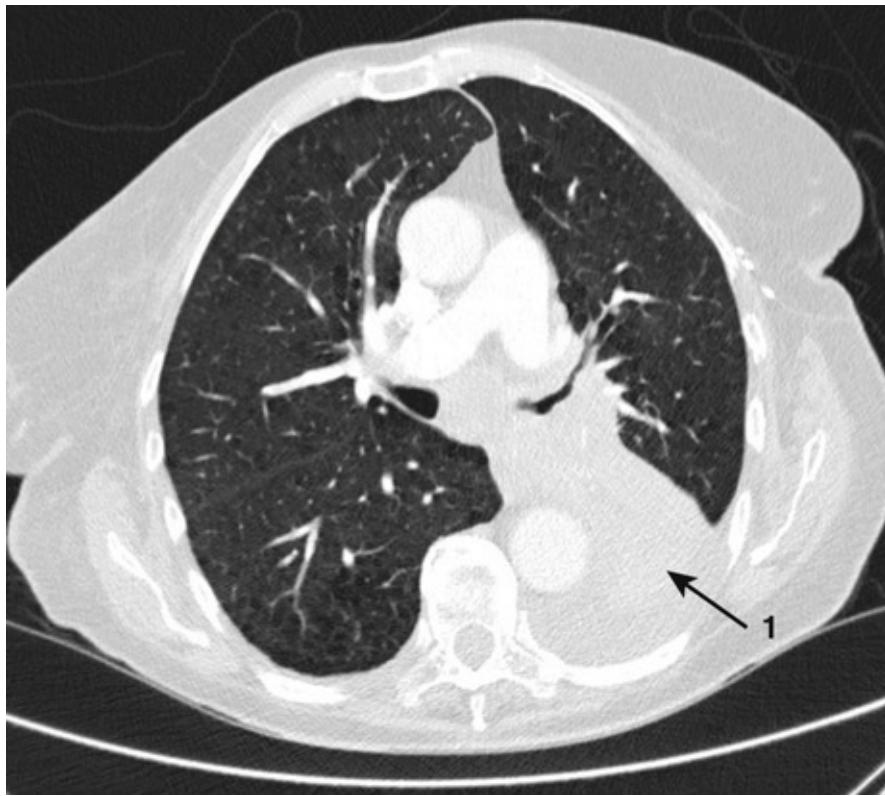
Left lower lobe collapse. Image shows the appearance of left lower lobe collapse on the lung windows of a CT scan. There is a dense opacity (1) in the left lung postero-medially with smooth curved edges and no air bronchograms. Contrast is visible in the aorta and pulmonary arteries.
